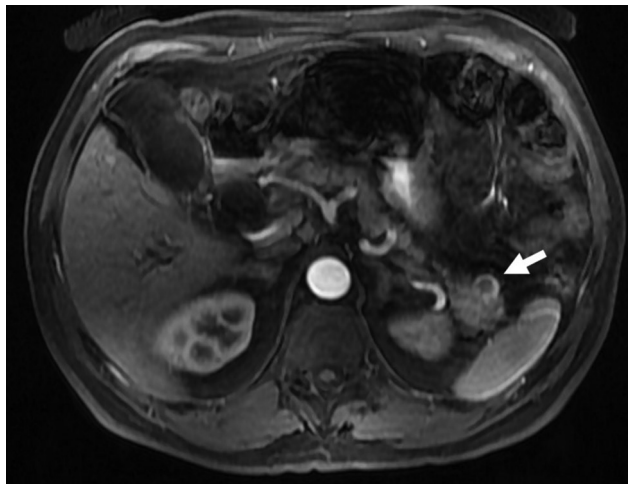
A 60-year-old male with incidental cystic pancreatic neuroendocrine tumor. Axial postcontrast T1-weighted image showing incidental unilocular cystic lesion (arrow) in the tail of the pancreas, showing peripheral arterial enhancement suggestive of cystic neuroendocrine tumor.
